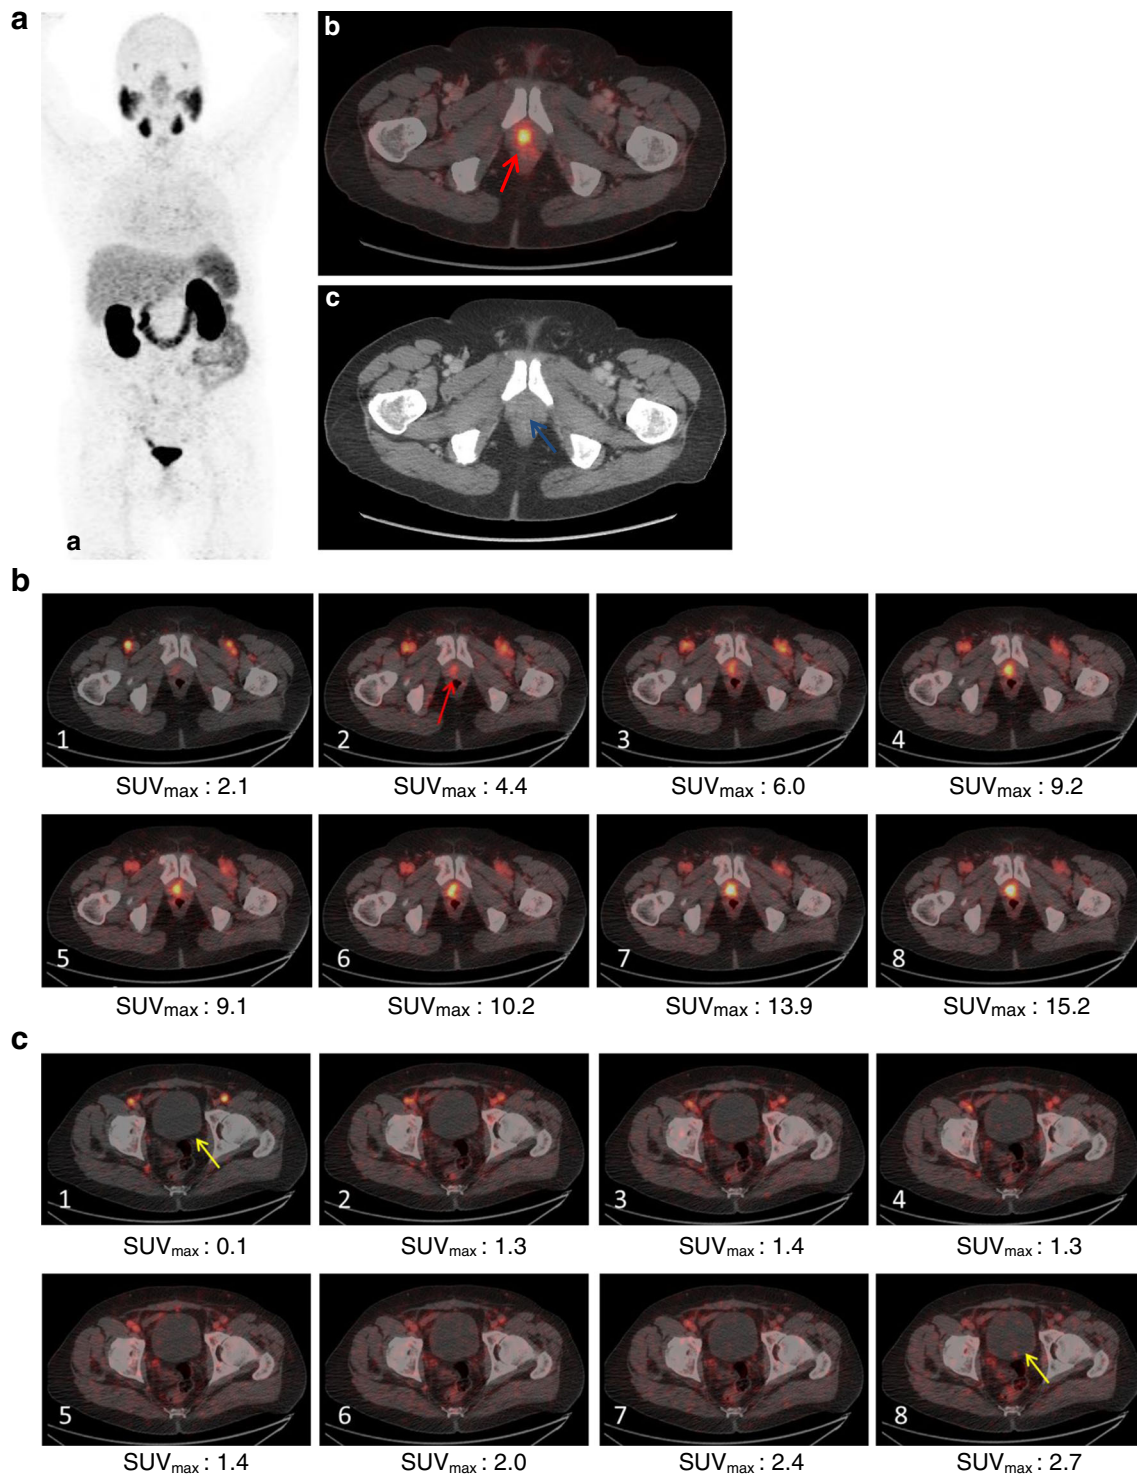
a ^{68}Ga -PSMA-11 PET/CT of a PC patient with biochemical recurrence (PSA: 4.46 ng/mL). b Maximum intensity projection (a), fused PET/CT (b), and ceCT (c) with markedly increased tracer accumulation adjacent to the urinary bladder (*red arrow*) with no pathologic finding on CT (*blue arrow*). A differentiation of physiologic urethra activity and local relapse was not possible. c Early dynamic PET comprising pelvic region of patient on Fig. 3a with fused PET/CT (low-dose CT) displaying an early and constantly rising focal tracer uptake at
